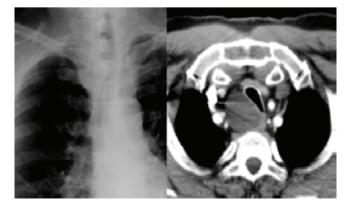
Posteroanterior chest X-ray and computed tomography (CT) image of bronchogenic cyst
